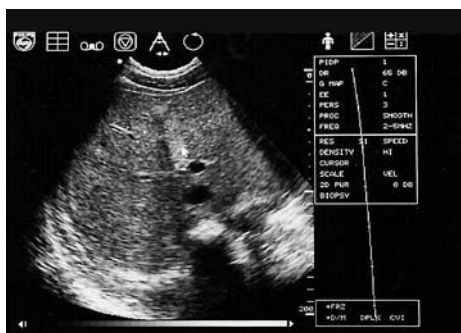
Abdominal ultrasound showing hyperecogenic nodules close together in the liver of the second patient.
